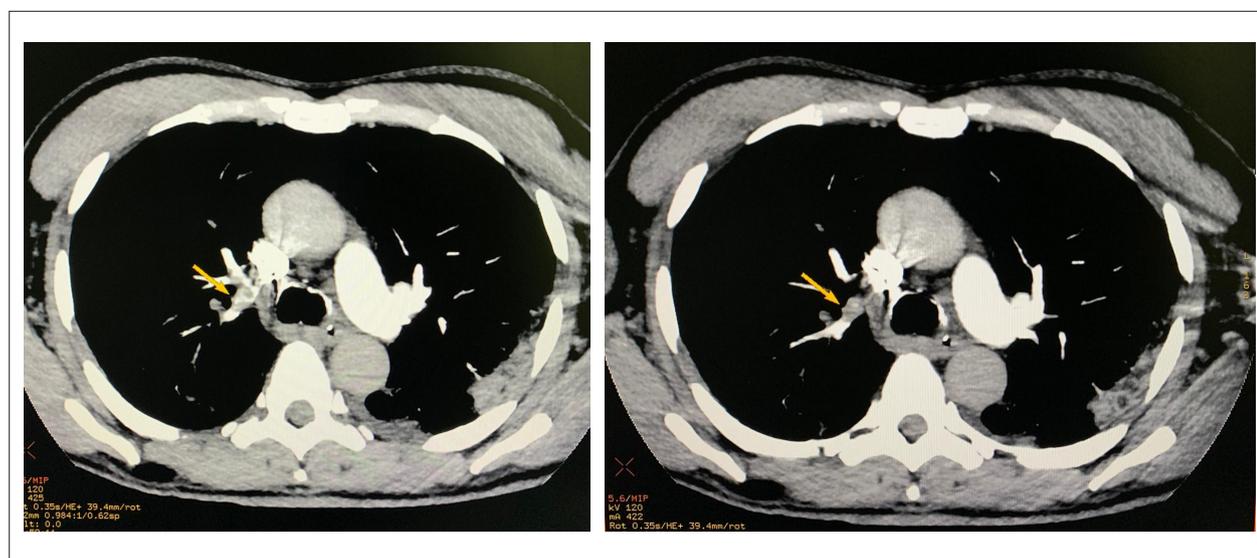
Computed tomography angiography of the chest: (yellow arrow) filling defect of the distal right pulmonary artery, extending to segmental branches of the right upper lobe, compatible with pulmonary thromboembolism.
